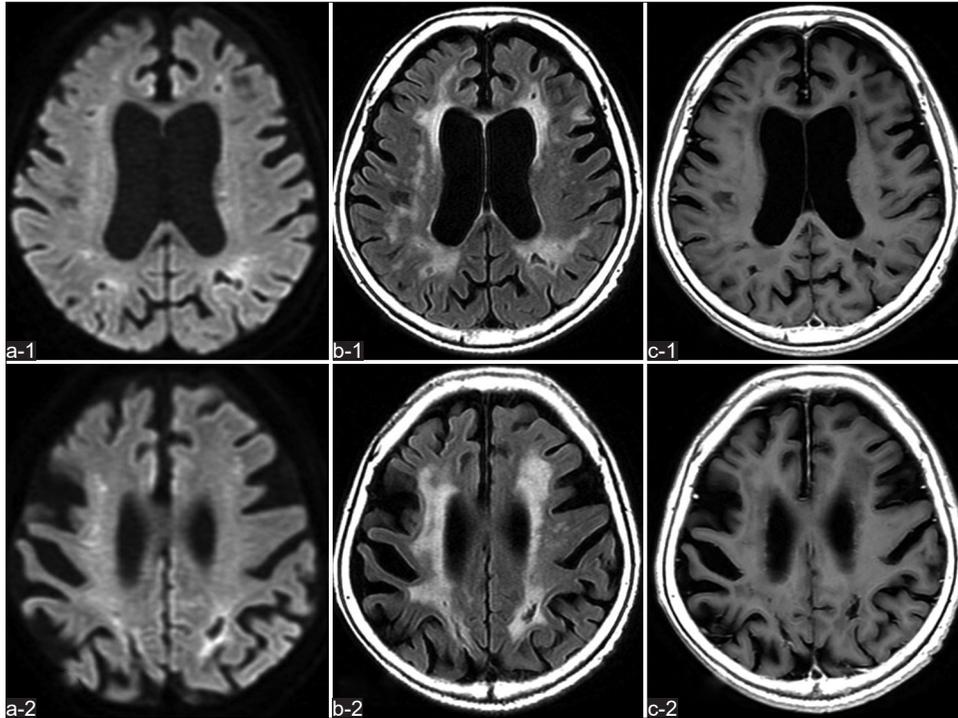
Brain magnetic resonance imaging (MRI) findings at 1 month after admission. The multiple high-intensity lesions apparent on MRI obtained at admission have decreased on diffusion-weighted imaging (a-1 - a-2), and no new lesions are identified on fluid-attenuated inversion recovery imaging (b-1 - b-2) and gadolinium-enhanced T1-weighted imaging (c-1 - c-2).
